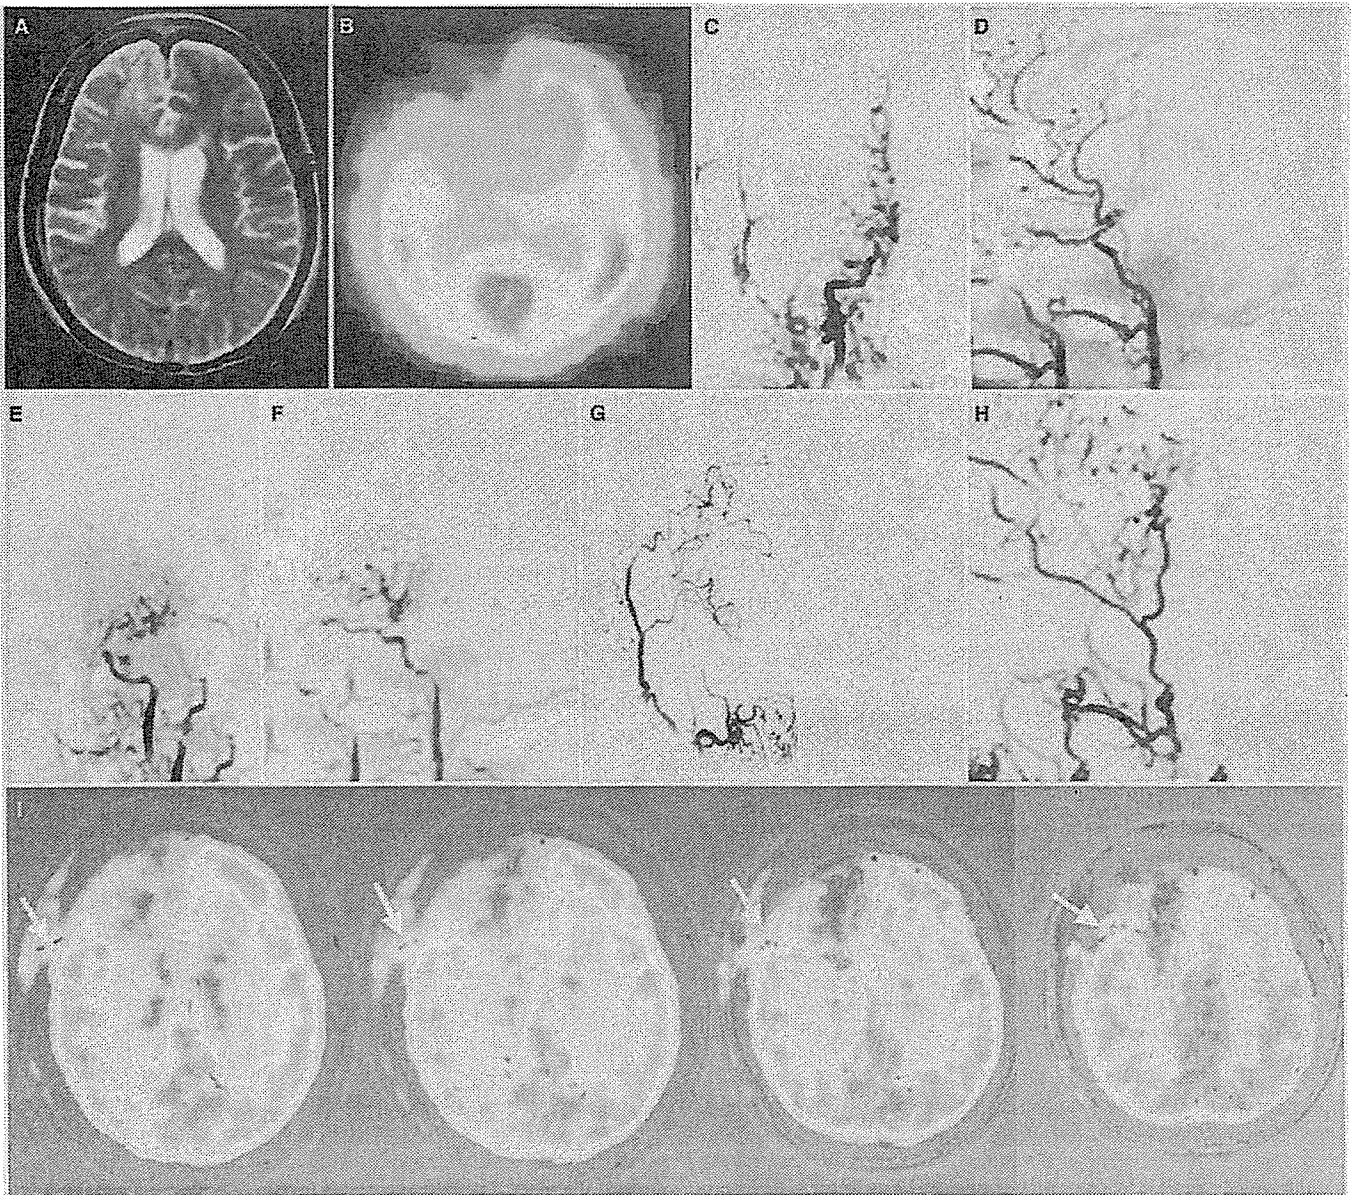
Right STA-MCA anastomosis for a 56-year-old woman (Patient 3) with moyamoya-like disease. A, T2-weighted magnetic resonance imaging scan obtained on admission demonstrating cerebral infarction in the right frontal lobe. B, a preoperative single-photon emission computed tomographic study revealing significantly decreased rCBF, mainly in the right frontal lobe. C–F, cerebral angiography revealing right
